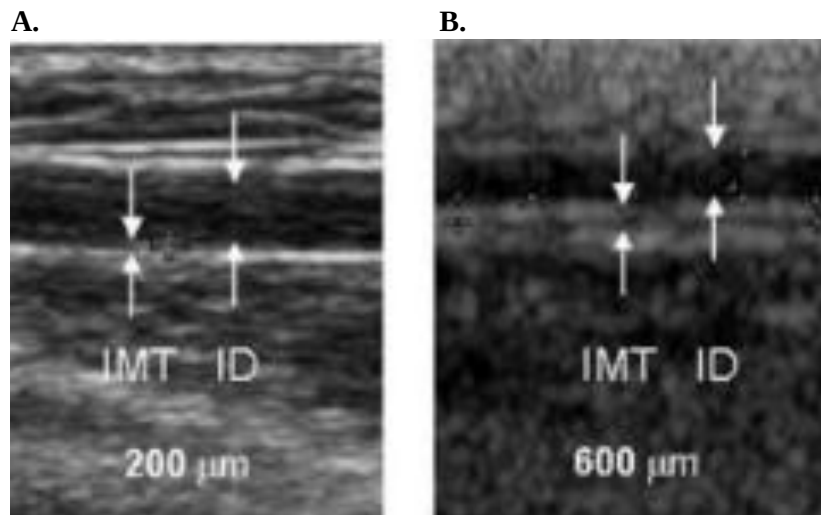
B-mode ultrasonography of the RIMT and internal diameter of the radial artery (Ku et al., 2006). A: Normal RIMT measurement. B: Abnormal RIMT measurement.*
